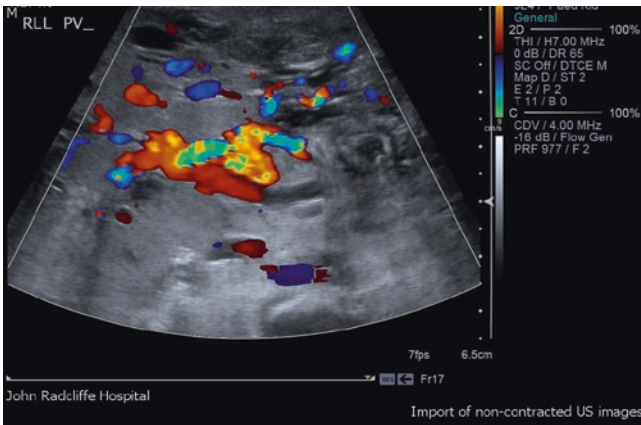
Ultrasound with Doppler of the liver reveals multiple hypoechoic lesions in both lobes of the liver with generalized hypertrophy of hepatic vasculature
